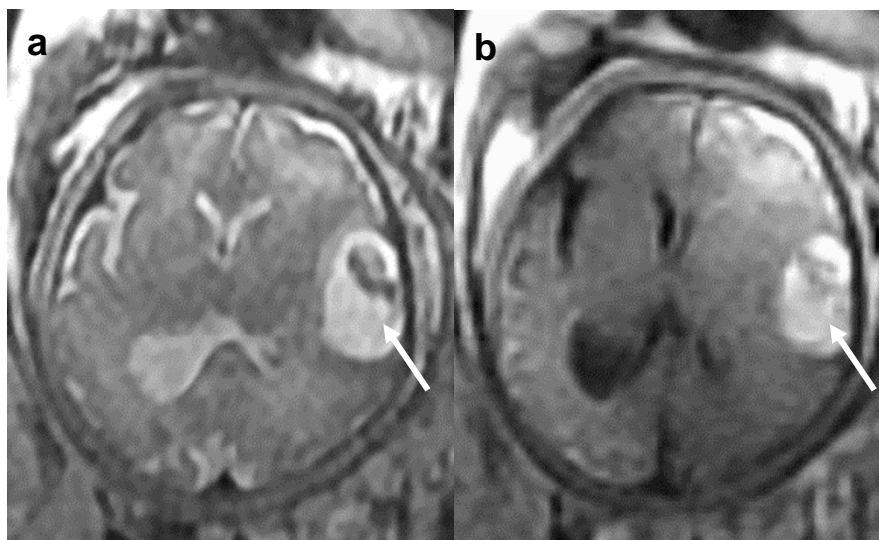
Images of a 35 weeks gestation fetus with right temporal lobe subacute haemorrhagic stroke (arrows) as a result of alloimmune thrombocytopenia (a) Axial T2 ssFSE and (b) Axial T1 weighted FLAIR images
